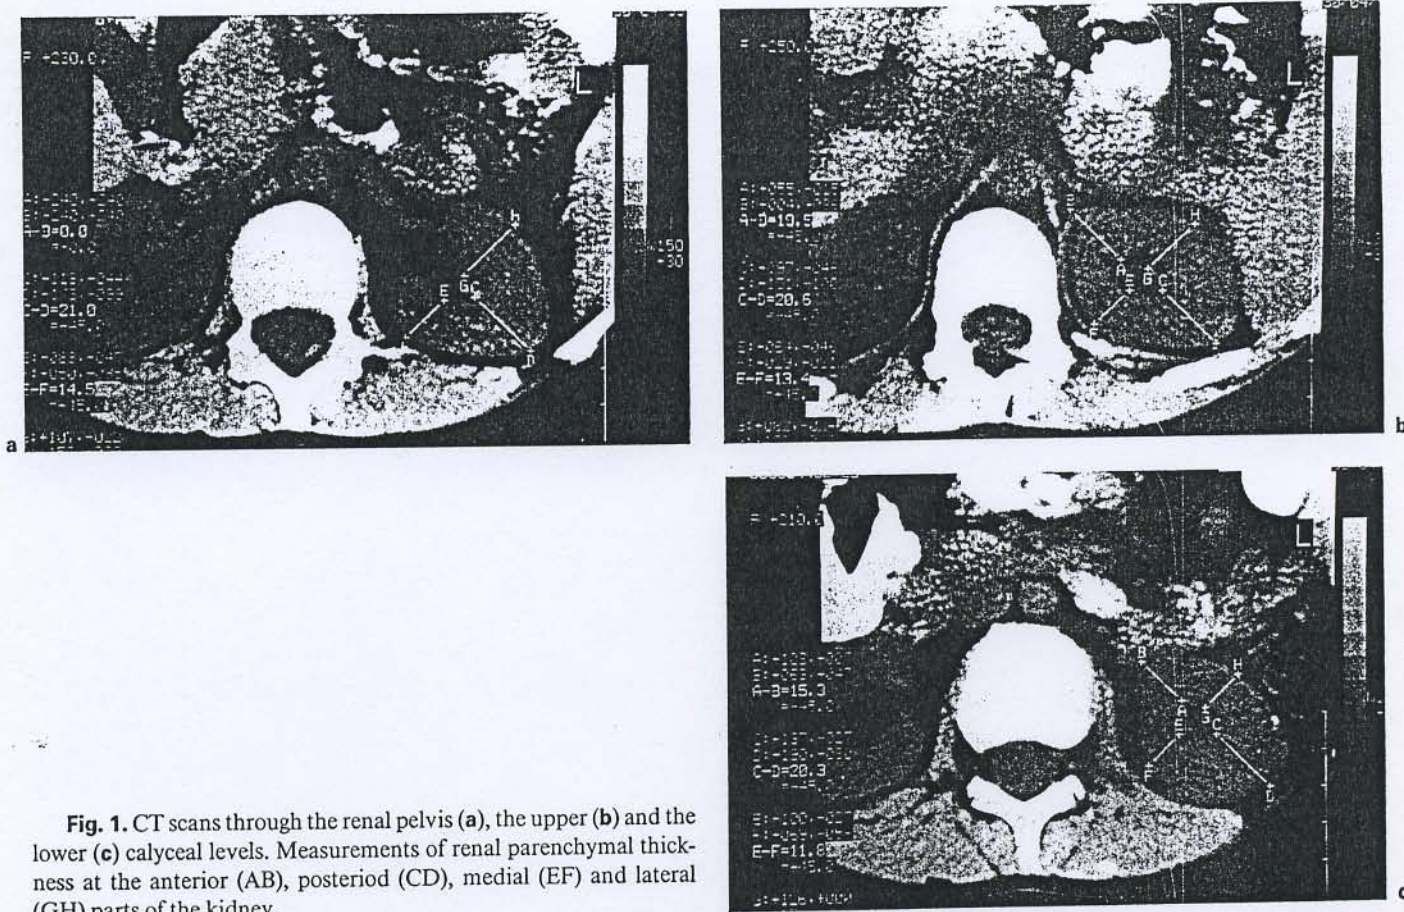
CT scans through the renal pelvis (a), the upper (b) and the lower (c) calyceal levels. Measurements of renal parenchymal thickness at the anterior (AB), posterior (CD), medial (EF) and lateral (GH) parts of the kidney.
